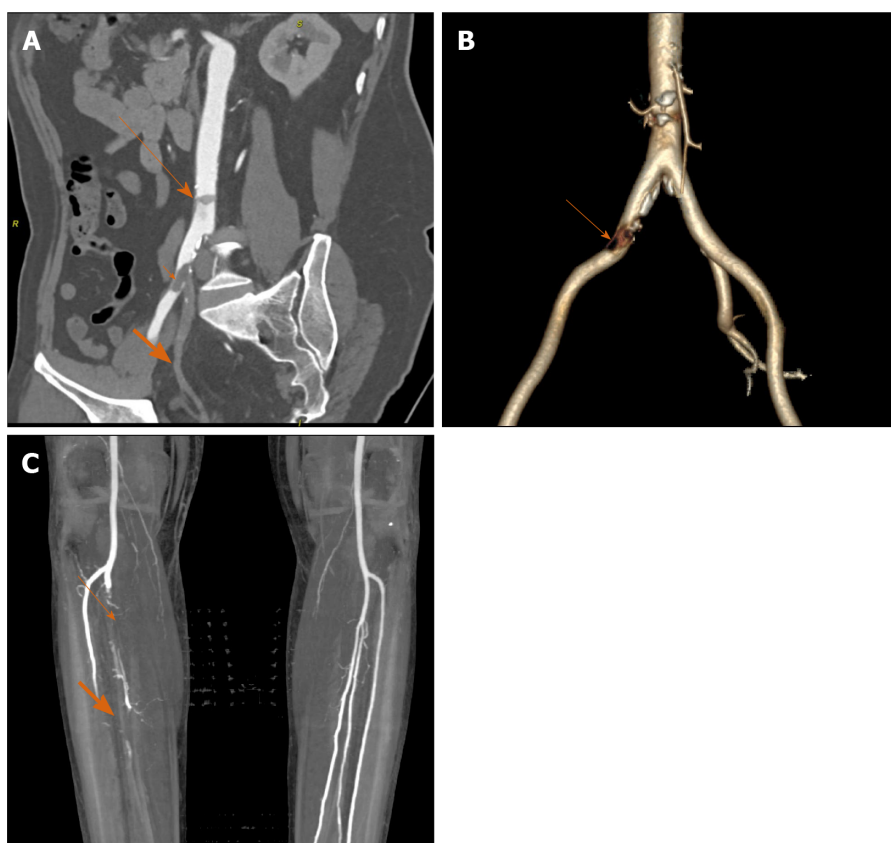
A 51-year-old male with peripheral arterial disease. A: Coronal oblique reformat image of contrast-enhanced computed tomography abdomen shows small mural thrombus in abdominal aorta (long arrow); and another partially occluding thrombus at right common iliac artery (short arrow) bifurcation extending into external iliac branch and synchronous complete thrombosis of right internal iliac artery (broad orange arrow); B: Three-dimensional reconstructed image shows defect in right common iliac artery and complete non visualization of right internal iliac artery; C: Coronal maximum intensity projection image of computed tomography angiography of bilateral lower limbs shows filling defect in right tibio-peroneal trunk just beyond origin with poor distal reformation (thin arrow), and non-opacification of mid and distal third of right anterior tibial artery (broad orange arrow).
